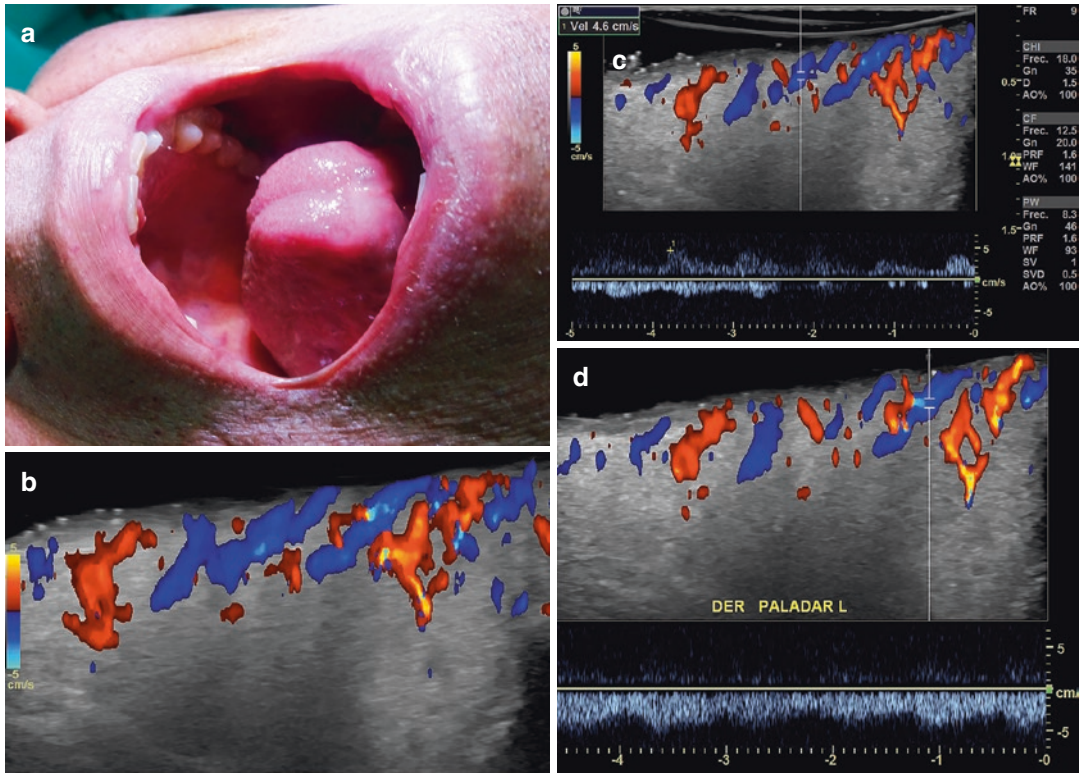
Osler-Weber-Rendu syndrome. (a) Clinical image of patient with a history of multiple bleeding episodes in the oral cavity and gastrointestinal system. (b) Color Doppler (longitudinal view of the palate) shows
